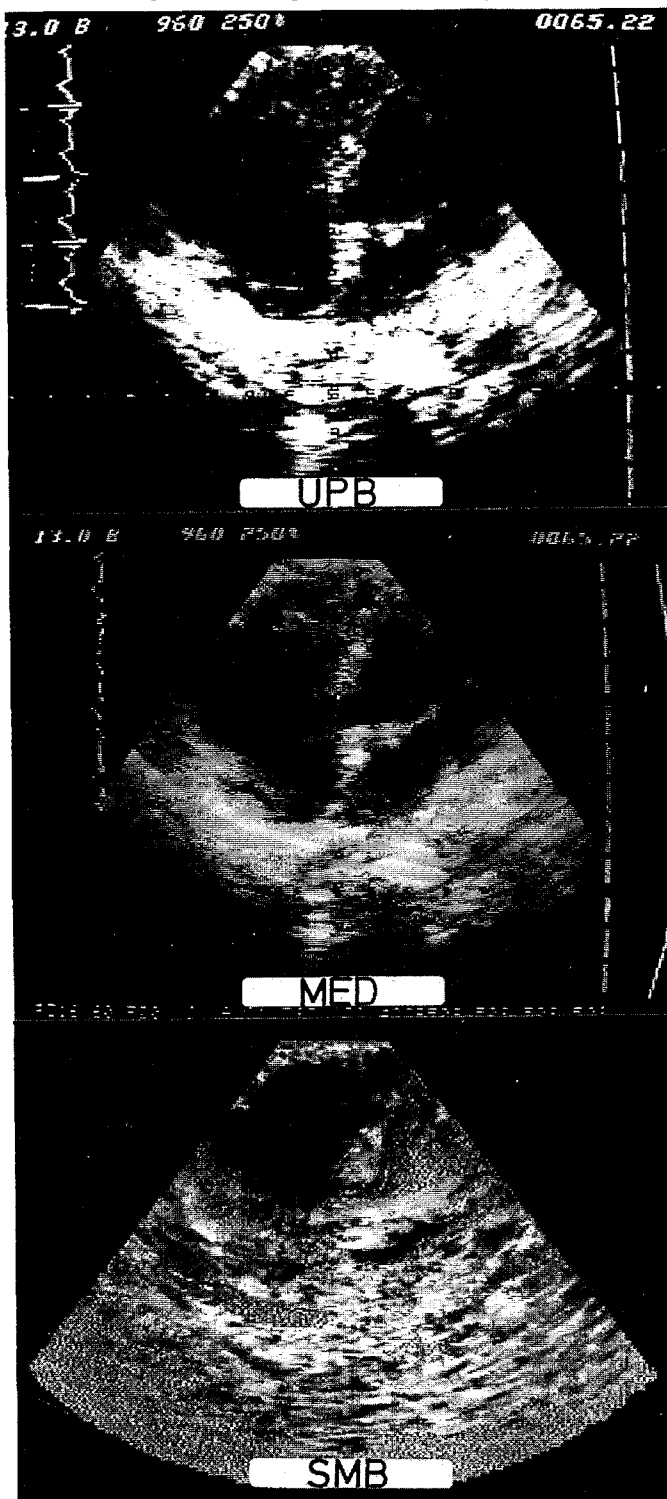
2D-echocardiographic 4-chamber views. Upper panel: unprocessed background (UPB); middle panel: processed background, median value (MED); lower panel: contrast subtraction image (SMB) after injection of cold normal saline into the right ventricle. Abbreviations: fig.1.
